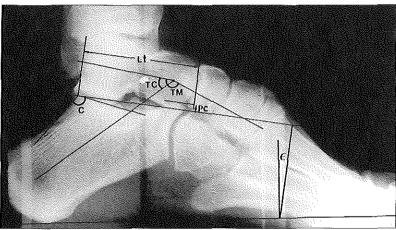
Radiographs of a foot with a slightly flattened longitudinal arch (above) in comparison with a foot with a high longitudinal arch (below).
